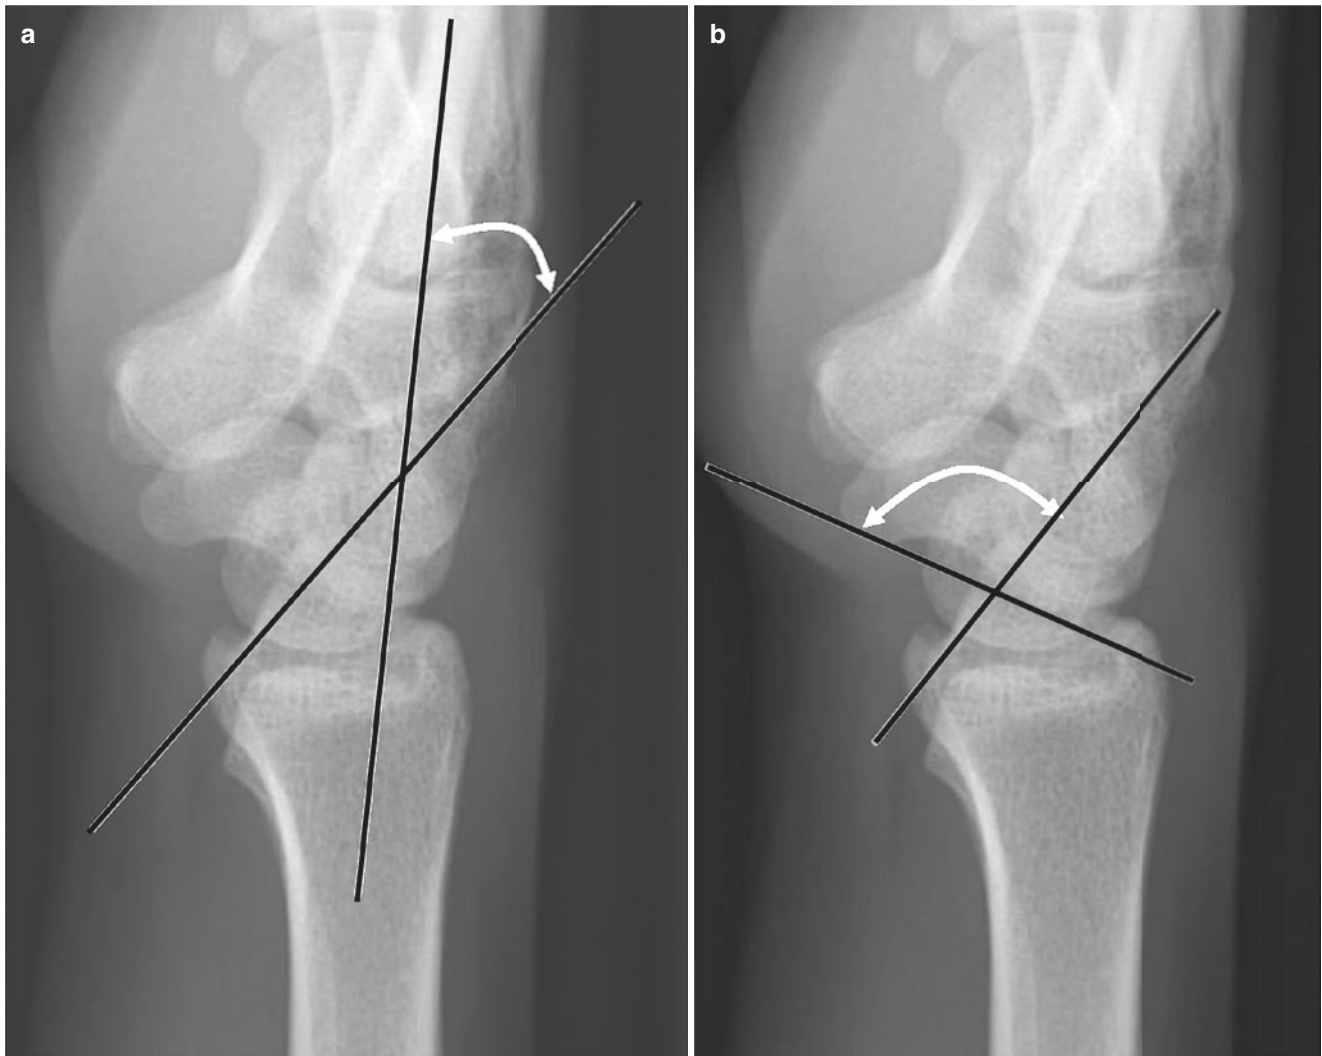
Lateral radiographs demonstrate volar tilt of lunate with widening of capitulunate angle $>30^\circ$ and scapholunate angle $>60^\circ$ (a and b, respectively) compatible with malalignment seen with dorsal intercalated segment instability (DISI)
